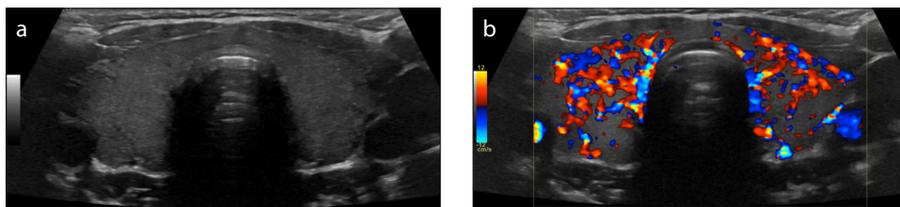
a, b. A 39-year-old man with metastatic RCC treated with HDIL-2. Ultrasound image (a) shows that the thyroid is mildly heterogeneous and hypoechoic. Color Doppler US image (b) demonstrates diffusely increased vascularity in the gland, consistent with thyroiditis. Thyroid function tests showed elevated thyroid stimulating hormone and low T4 levels. The patient was started on levothyroxine.
